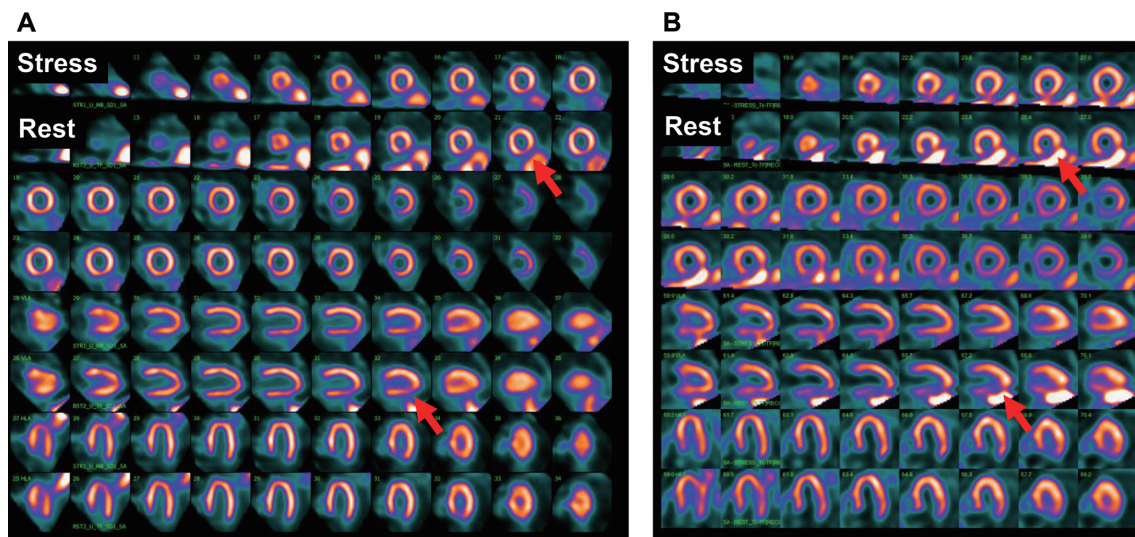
Short axis, vertical long axis, horizontal long axis images of D-SPECT and GCA9300R.
